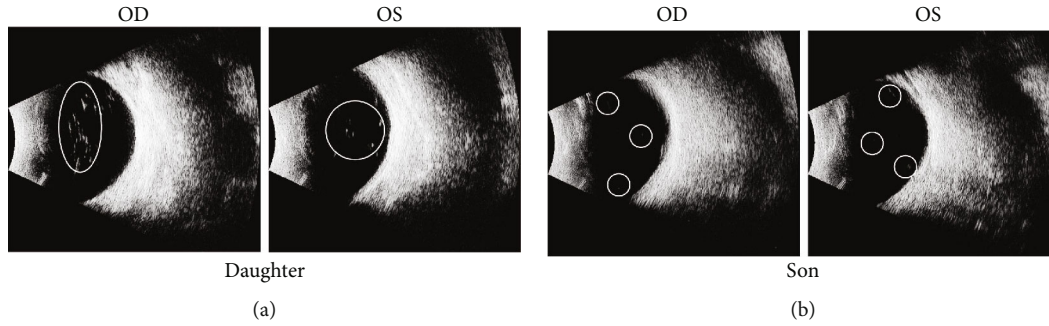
Ocular ultrasound images. (a) Vitreous bodies with mild opacity of the daughter. (b) Vitreous bodies with mild opacity of the son. The daughter's vitreous opacity was more pronounced and none of them found the lens.
